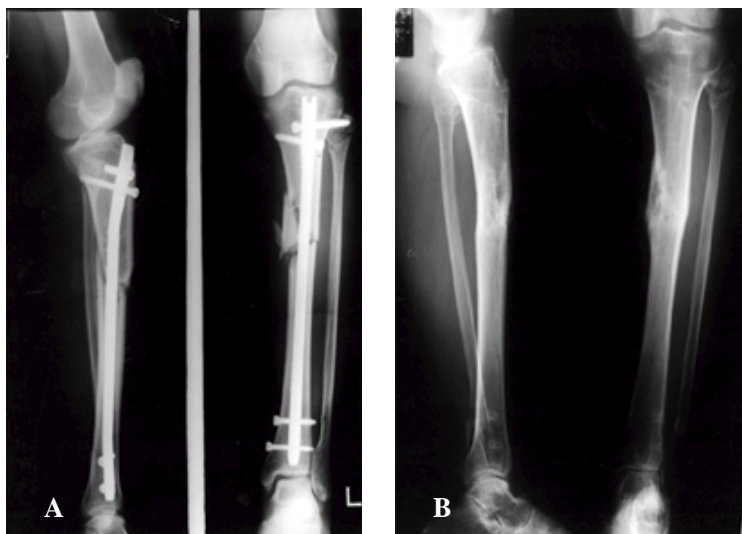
Immediate postoperative radiographs show a comminuted fracture of tibial shaft. Note that nail insertion site is in a position of 58% in anterior radiograph and 36% in lateral radiograph
